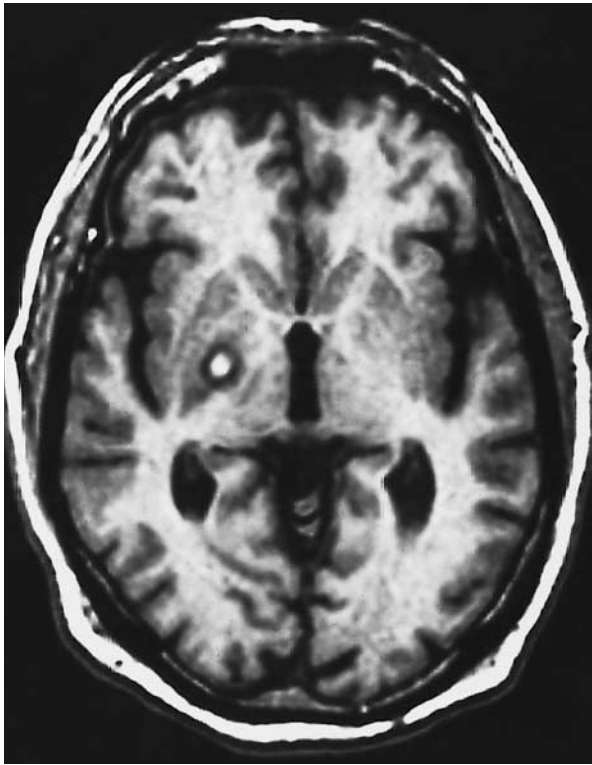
Axial T₁-Weighted MRI Scan Showing a Right-Sided Lesion in the Posteromedial Portion of the Globus Pallidus.
